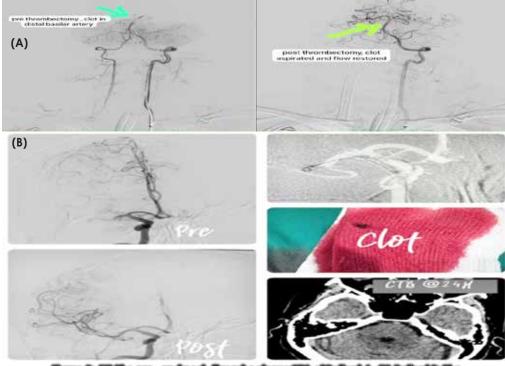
(A) The pre- and post- thrombectomy CTA of Patient A. (B) Patient B: The following collage showing pre- and post-thrombectomy CTA; The clots retrieved is seen on the gauze; A 24-hour post MT CT brain showing no intracranial bleed
